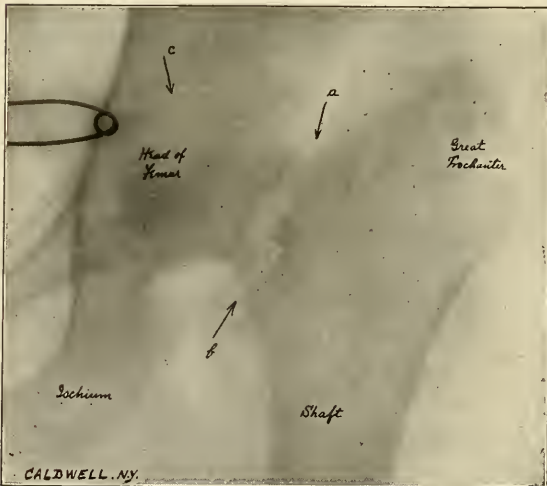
Case of Dr. Royal Whitman, N. Y. A girl sixteen years old. Injured by a fall from a carriage. Fracture of the neck of the femur. This X-ray was taken six months following the accident. Note that the arrows *a* and *b* point to the seat of fracture. The arrow *c* almost touches at its tip the rim of the acetabulum and the rounded head of the femur.
